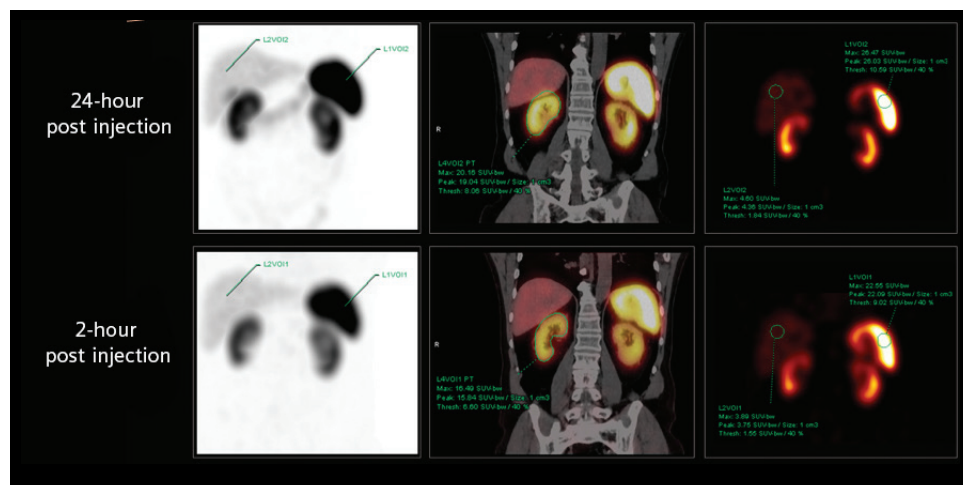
Sequential quantitative ^{111}In -octreotide SPECT/CT studies in a NET patient without metastases showing gradual increase in renal and splenic uptake activity over the course of 24 hours.
